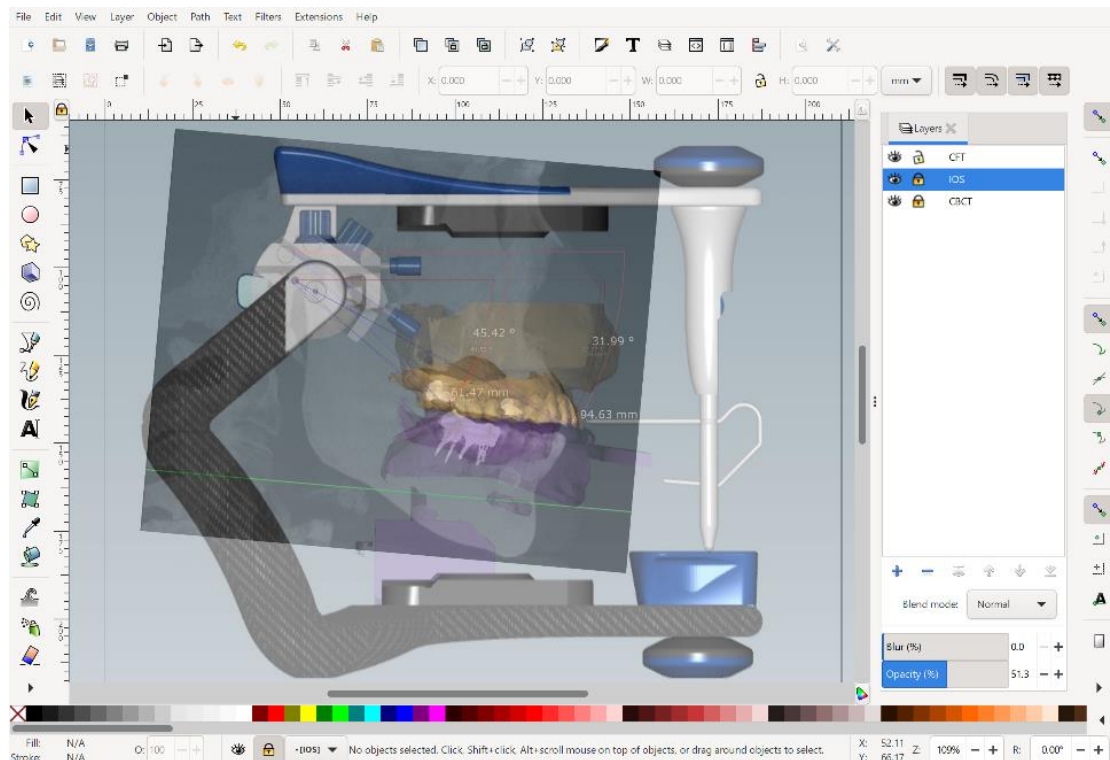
Calibration and measurement of superimposed digital files from CBCT image, CFT method, and IOS method in Inkscape software 1.1.1
